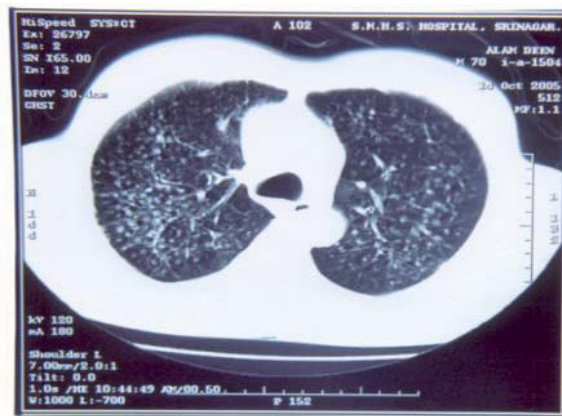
High resolution computed tomography (HRCT) scan of chest showing well defined miliary shadows, with diffuse distribution.
